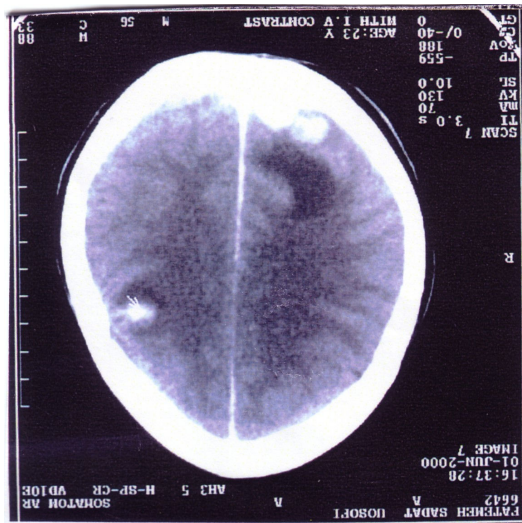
Brain CT-Scan :Hypodense mass in occiput region.
